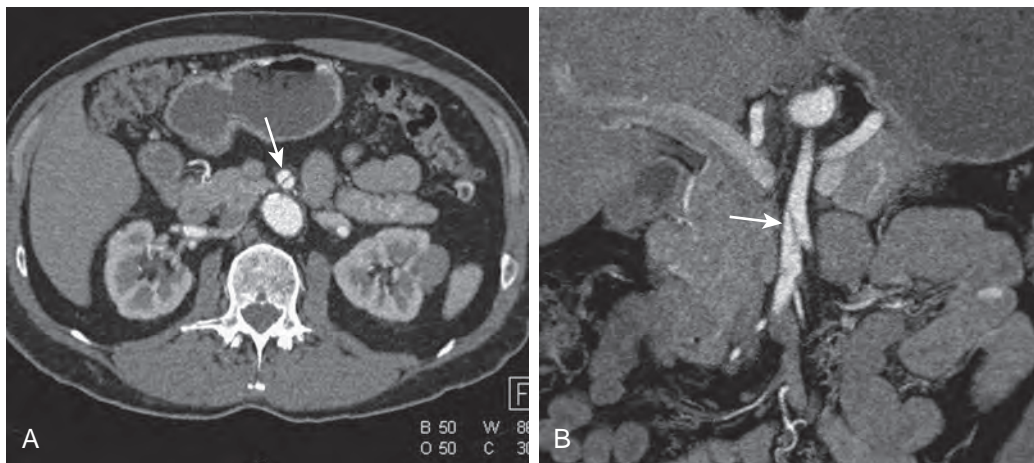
Dissection involving the superior mesenteric artery. Axial contrast-enhanced CT (A) and coronal volume-rendered (B) images demonstrate a dissection (arrows) involving the superior mesenteric artery
